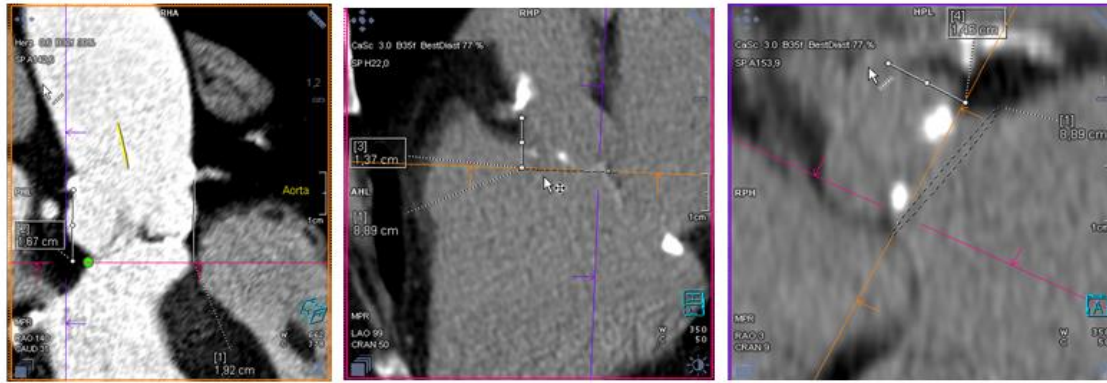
the difference between the estimation of the height of coronary ostiae in CT with and without contrast medium.
